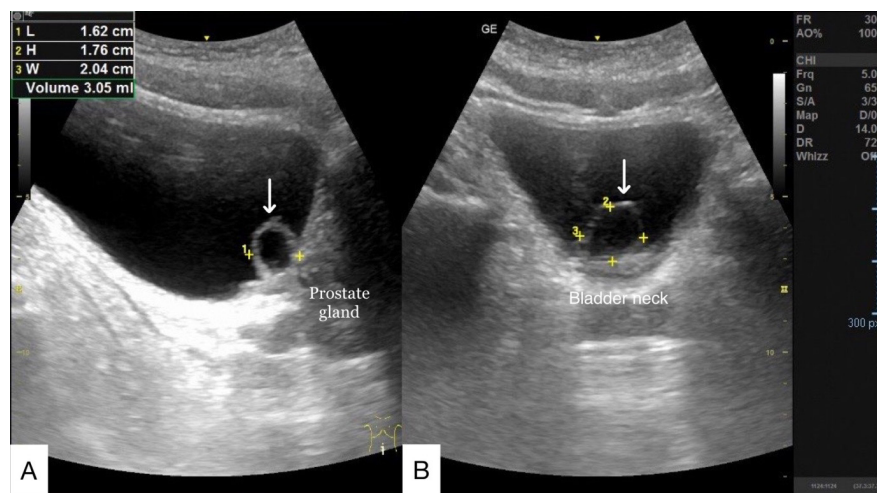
Bladder ultrasound showing cystic lesion at the bladder neck, size 1.62x1.76x2.04 cm (arrows). (A) Longitudinal view. (B) Transverse view.
